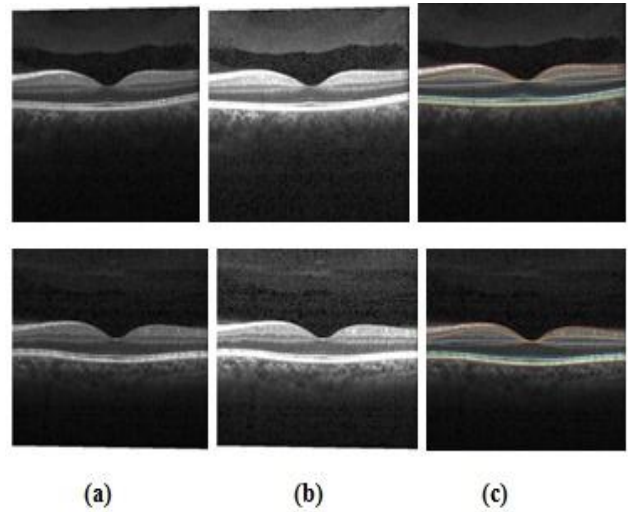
(a) Input MRI images, (b) contrast-enhanced images using CLAHE, and (c) segmented regions using the ICSW-WS.
